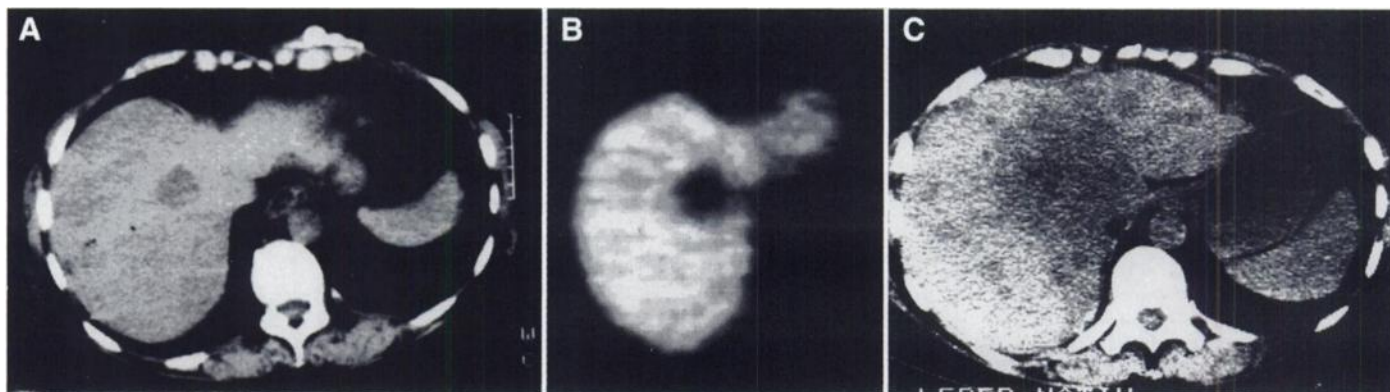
(A) CT cross section of patient with small liver metastasis in central part of cranial third of right liver lobe. Scan was performed before initiation of chemotherapy. (B) PET cross section 120 min after systemic application of ^{18}F -FU. PET scan demonstrates low trapping of ^{18}F -FU 120 min postinjection (1.91 SUV). Metastasis is delineated as defect against normal liver parenchyma. (C) CT follow-up 11 mo after initiation of FU chemotherapy. There is tremendous increase in tumor volume, which is in accordance with low ^{18}F -FU trapping values noted before therapy.
